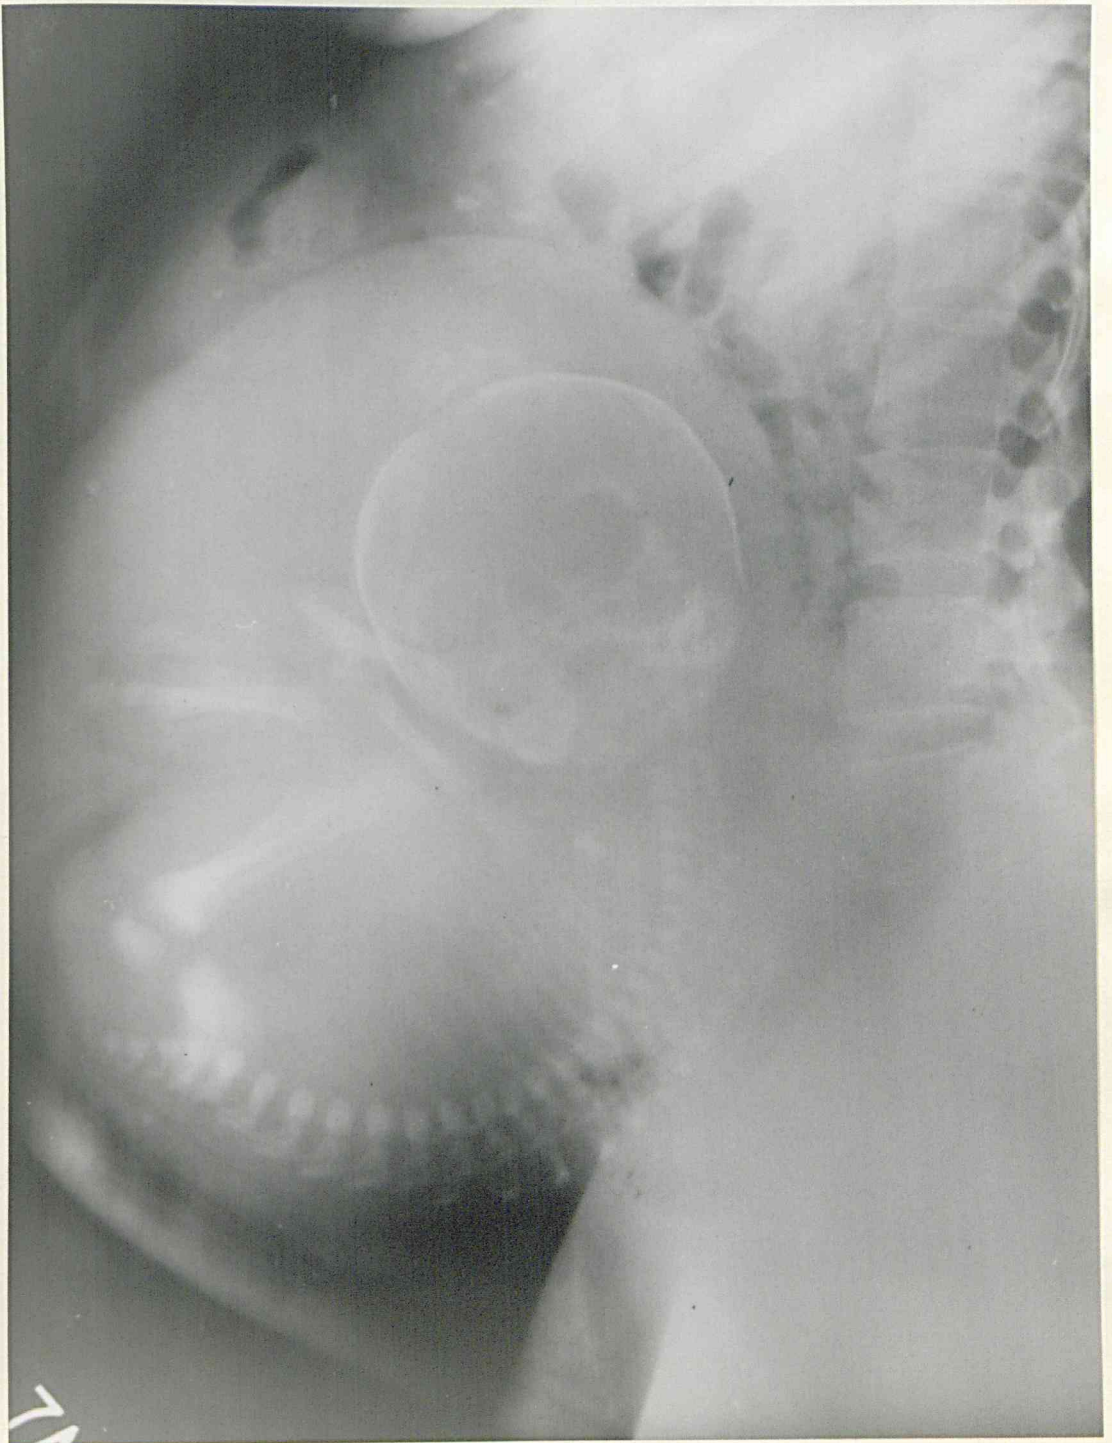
Lateral radiograph of the abdomen in a case of transverse lie. The placenta is shown in the fundus of the uterus as a thickening of the soft tissue shadows (Case No. 221).
